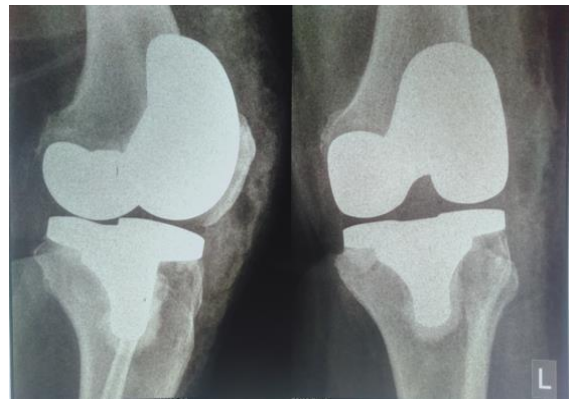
X-ray of the patient's left knee after total knee arthroplasty.
